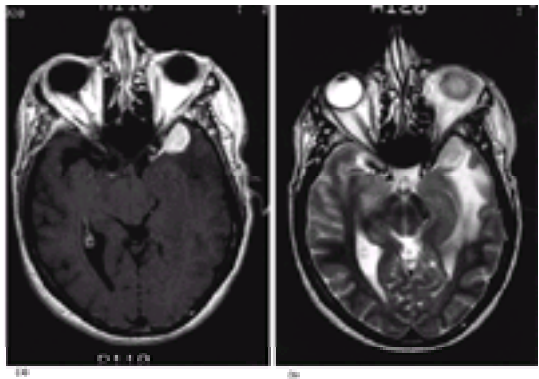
(a) Contrast-enhanced axial T₁-weighted MRI of a meningioma of the medial sphenoid wing; (b) T₂-weighted MRI of the same case—note the extensive hyperintense signal abnormality in the temporal lobe adjacent to the tumor.
